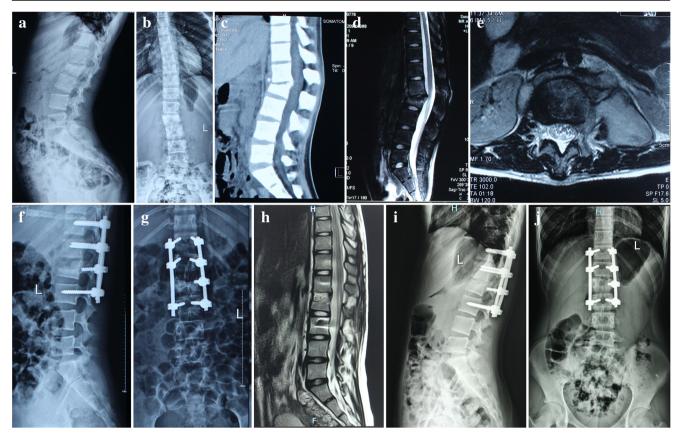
a-e A 12-year-old girl who had tuberculosis in L1-L2. Preoperative X-ray showed that kyphosis was 24° and the vertebral body collapse on L1-L2. MRI and CT showed that lesion around vertebral body of L1-L2 developed a great abscess with marked bony
